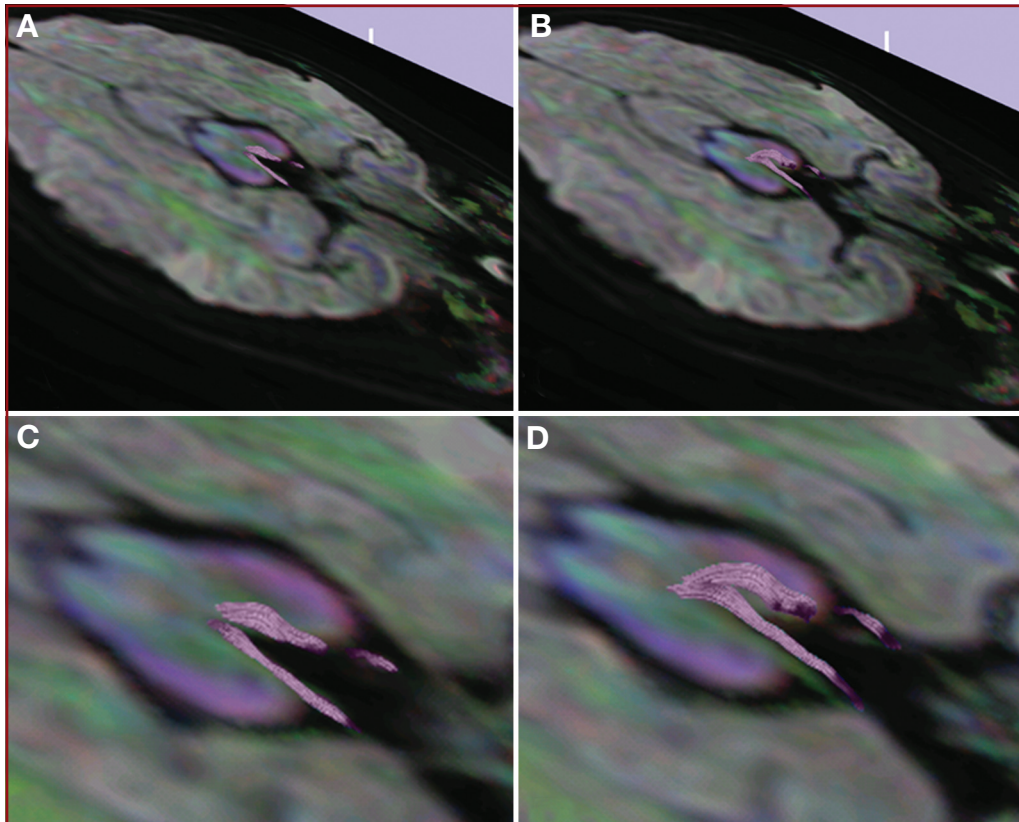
Three-dimensional representation of the oculomotor fibers (cranial nerve III) onto mixed anatomic/color-by-orientation MRI slices. The oculomotor fibers are seen exiting the midbrain. C and D, magnified images of A and B, respectively. Slight flaring of the fibers is seen as these approach the nucleus within the substance of the midbrain.
